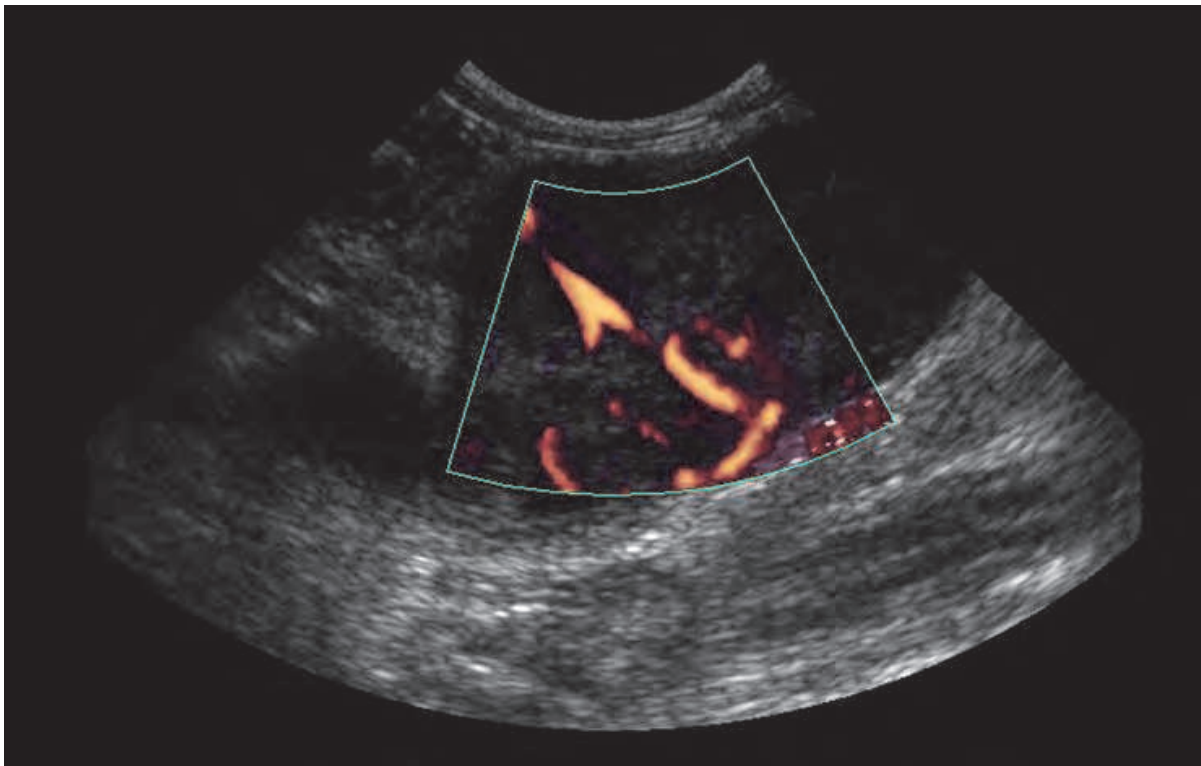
Metastasic Abdominal lymph node. The vessels could not be displayed using color Doppler, however the Power Doppler used in the image had sensitivity enough
